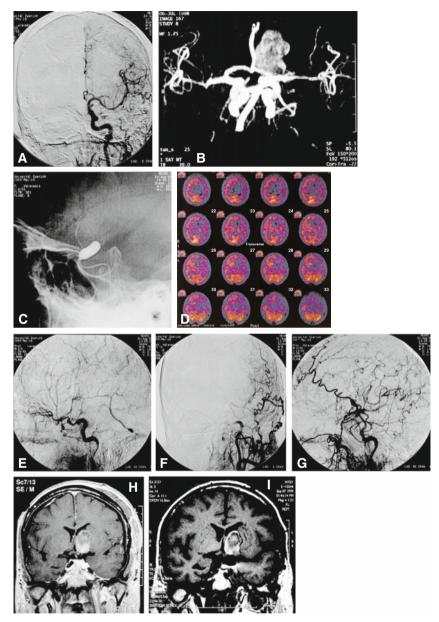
74-year-old male suffering from a growing mostly thrombosed giant aneurysm of the left ICA (A, B). He underwent the BOT (C), which was well tolerated but associated with asymmetry in SPECT (D). He underwent a standard STA-MCA bypass in combination with carotid occlusion just distal to the origin of the ophthalmic artery without any postoperative problems (E). The 3-month follow-up angiography showed an excellent filling of the MCA through the STA (F, G) and shrinkage of the thrombosed aneurysm (H, preoperative; I, one year postoperative)
